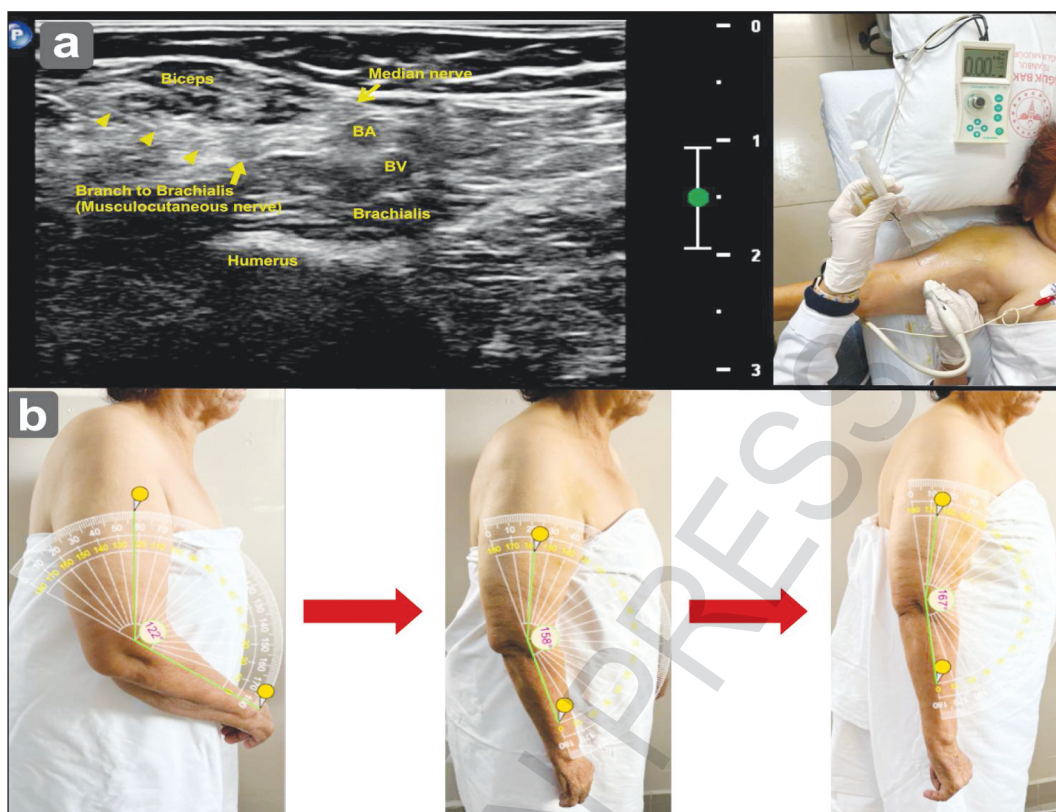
a) Ultrasound and electrical stimulator-guided selective block of the brachialis branch of the musculocutaneous nerve.
